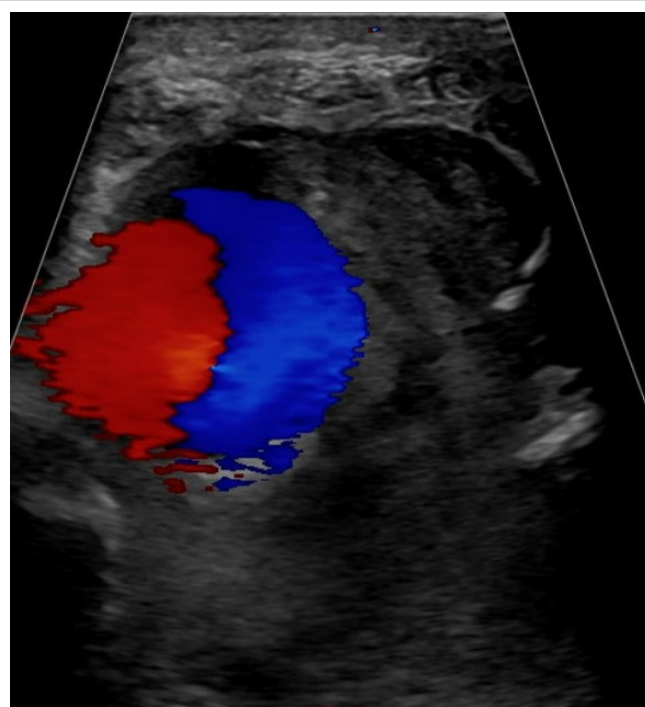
Color Doppler ultrasound shows a large, rounded structure with a classical yin-yang sign arising from the region of the anterior tibial artery.
